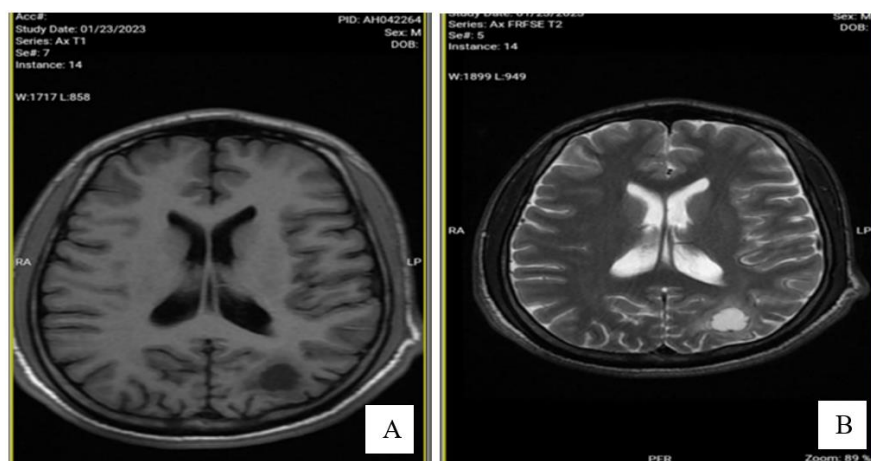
Axial magnetic resonance images of a 23 year old male managed for neurocysticercosis (A) T1 Image showing isointensity of the lesion. (B) T2 image showing hyperintensity.
